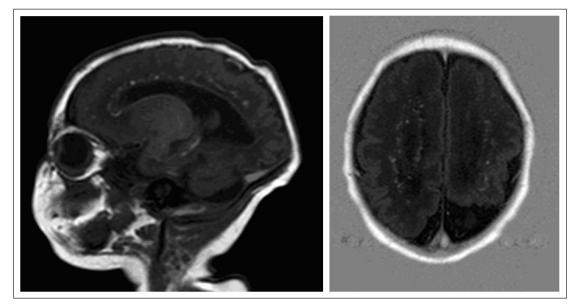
Cranial MRI scan showing cortical and subcortical calcification, venriculomegaly, increased cisterna magna, reduced cerebral convolution and diffuse hyperechoic spots.
